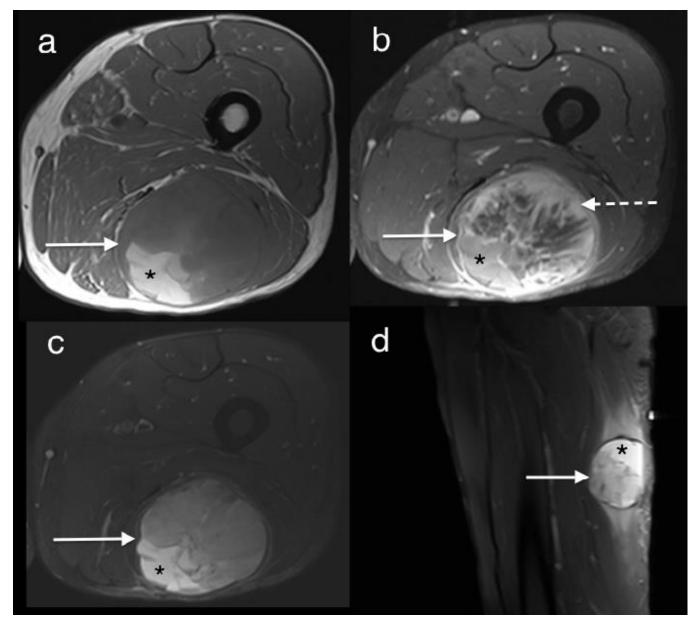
63 year old male with extraskeletal osteosarcoma. Siemens Symphony 1.5 Tesla MRI: (a) Axial T1 (TR: 1140 msec, TE: 12 msec), (b) fat saturated T1 weighted image (TR: 530 msec, TE: 12 msec) after 19 cc of IV Omniscan gadolinium, (c) axial and (d) sagittal fat saturated FSE T2 weighted images (TR: 3500 msec, TE: 60 msec), demonstrate a 7 x 8 x 7.5 cm enlarged well circumscribed soft tissue mass (solid arrow) that does not involve the femur, but contains hemorrhage (asterisk) and enhancing solid component (dashed arrow).
